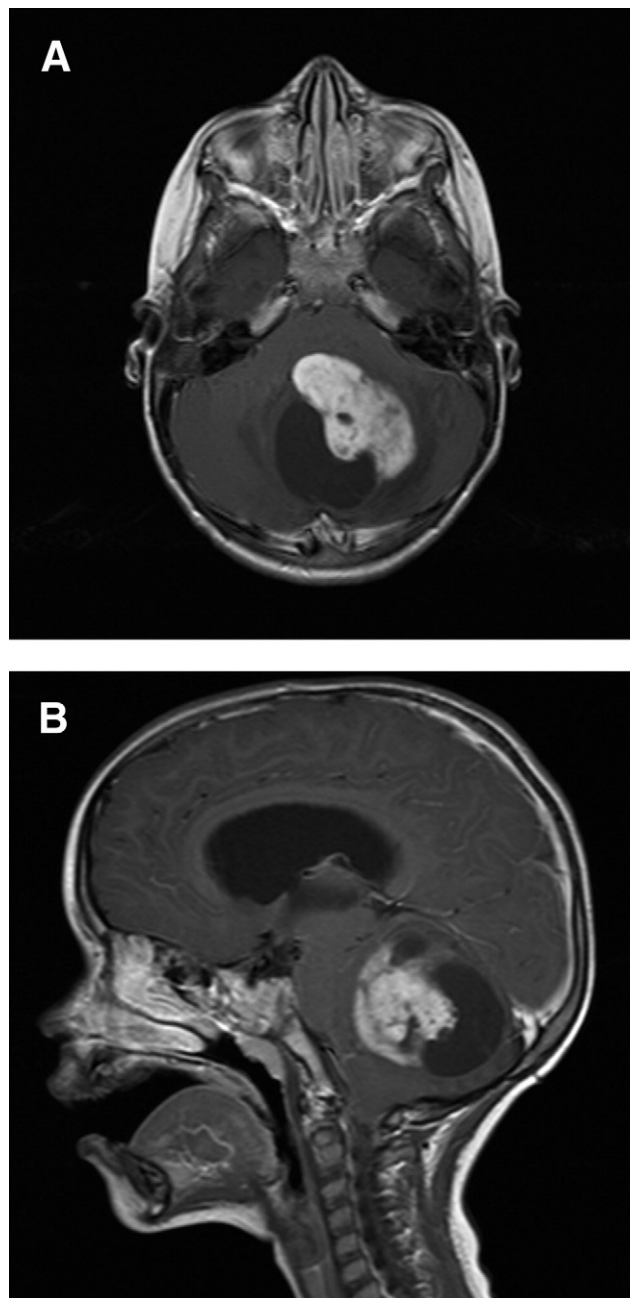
Cerebellar PA. T1 MRI with gadolinium. (A) Axial. (B) Sagittal. Note the classic cystic appearance and the solid enhancing component (courtesy of the Radiology Department BCCH).
